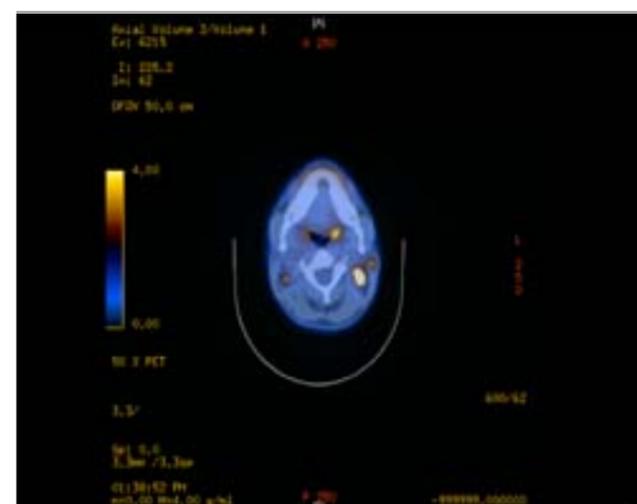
PET/CT scan of a patient with extranodal NK/T-cell lymphoma shows metabolically active disease present on both sides of the neck (maximum SUV, 11)
